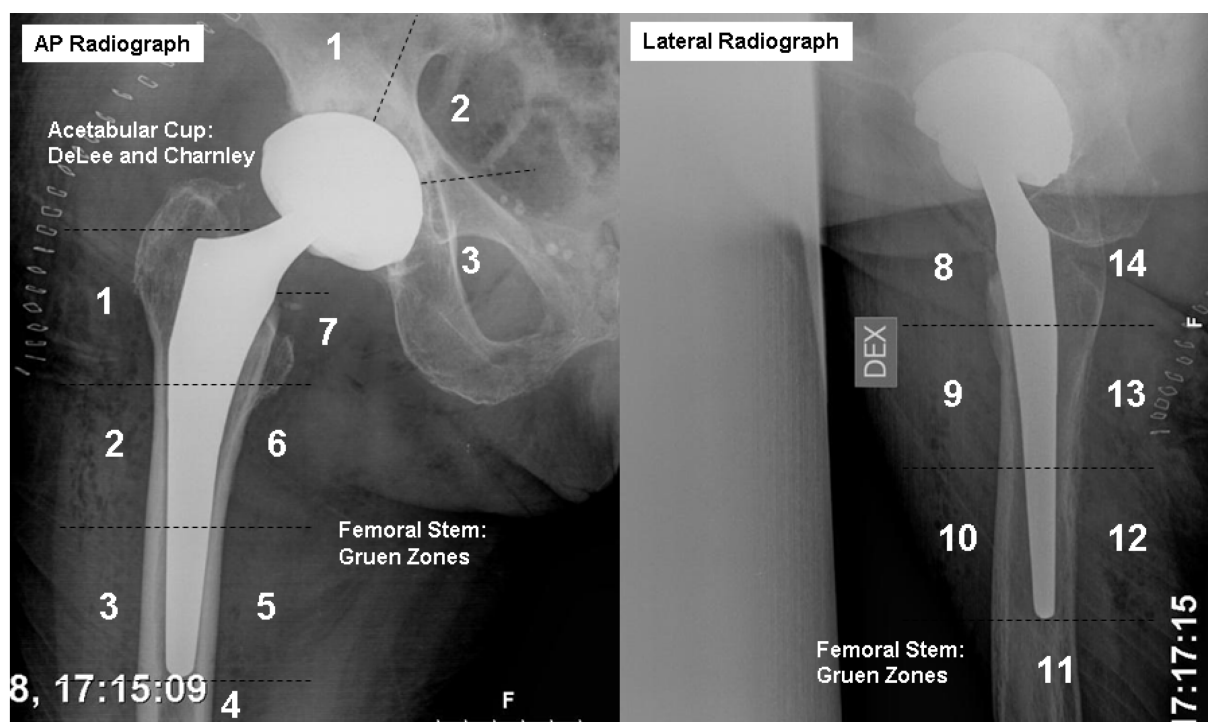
Radiographic zones for assessment of femoral and acetabular component radiolucency.
